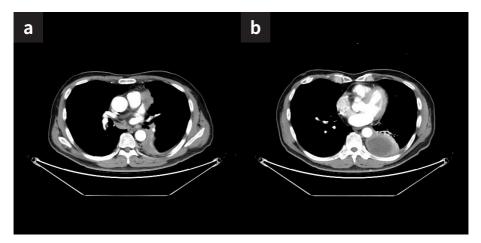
Computed tomography revealed stable disease after second-line chemotherapy.
